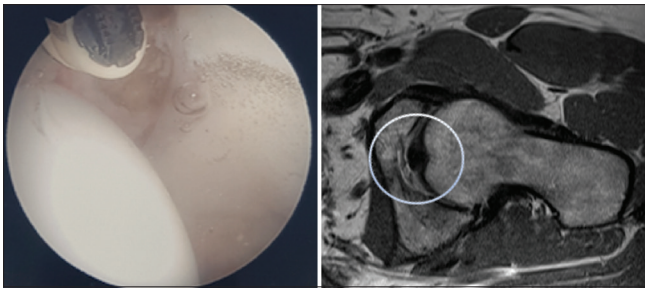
Demonstrates the comparable MRI image to arthroscopic finding of an acetabular cartilage wear. MRI: Magnetic resonance imaging
